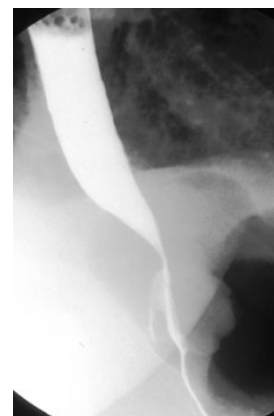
Post-operative Barium swallow X-ray (lateral view) after anterior 180° partial fundoplication. The oesophagus lies in a relatively straight (anatomical) position and is not lifted forward by placing the fundus behind the oesophagus
